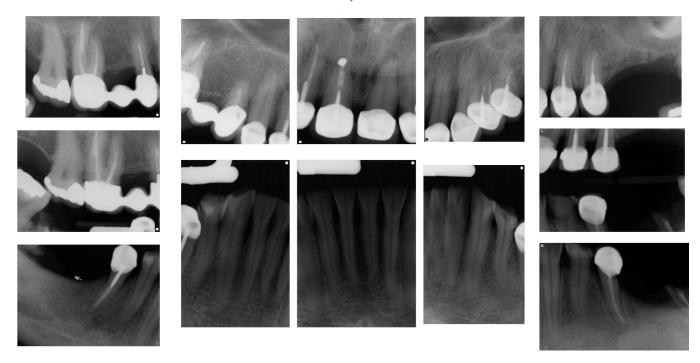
Radiographs charting prior to treatment.
